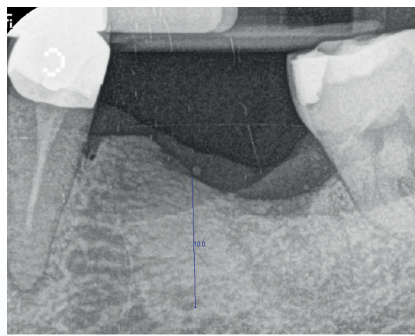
Control x-ray after 8 months.
